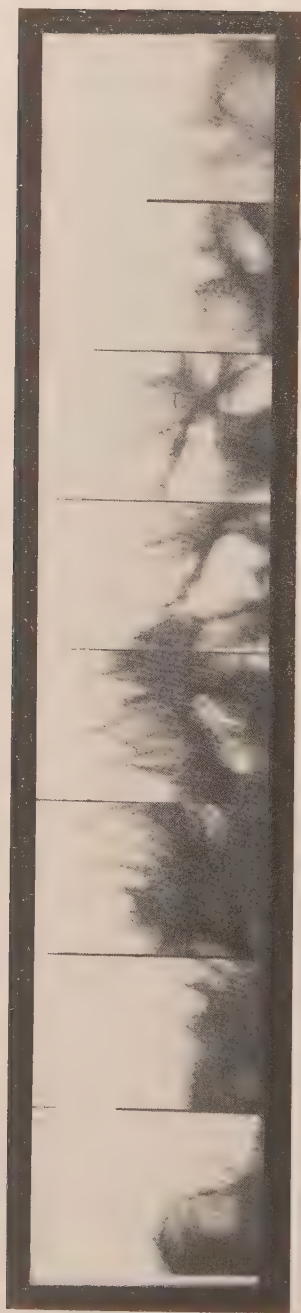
Radiograph of spinous process following a comparatively recent extraction.
